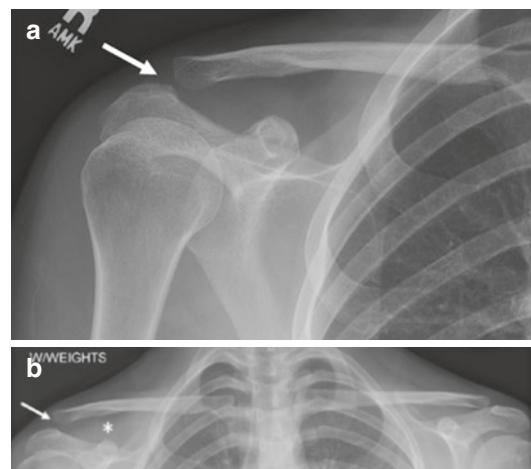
Twenty-four-year-old woman with acromioclavicular separation. AP radiograph (a) of the right shoulder demonstrates questionable offset of acromioclavicular alignment (arrow). AP view including both clavicles with weights (b) shows asymmetric progressive malalignment of the right acromioclavicular joint (arrow) with widening of the coracoclavicular distance (asterisk), consistent with a type III acromioclavicular separation injury
